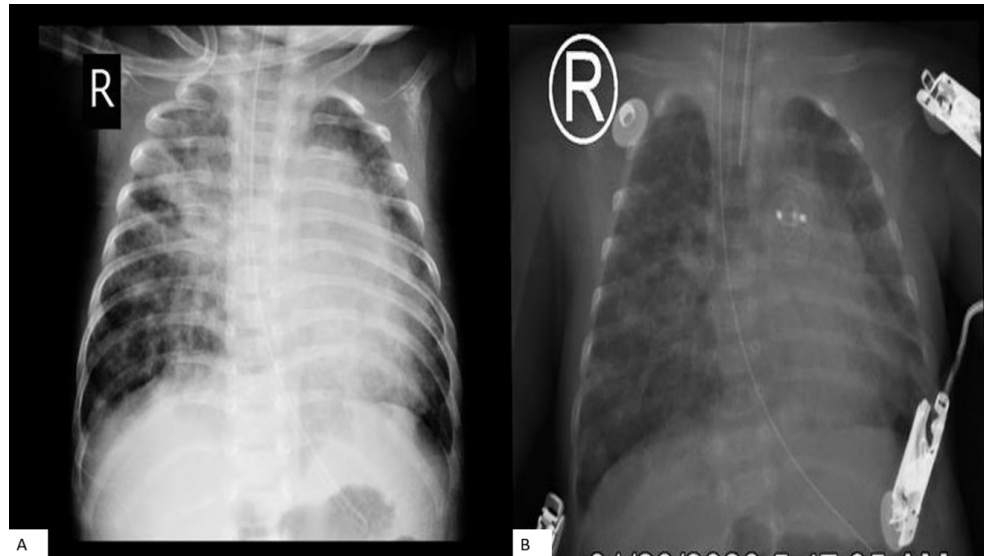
Picture A shows chest radiography prior to device closure. Picture B shows chest radiography 24 hours post device closure with noted significant decreased in pulmonary congestion and heart size. The device was noted to be in place.
